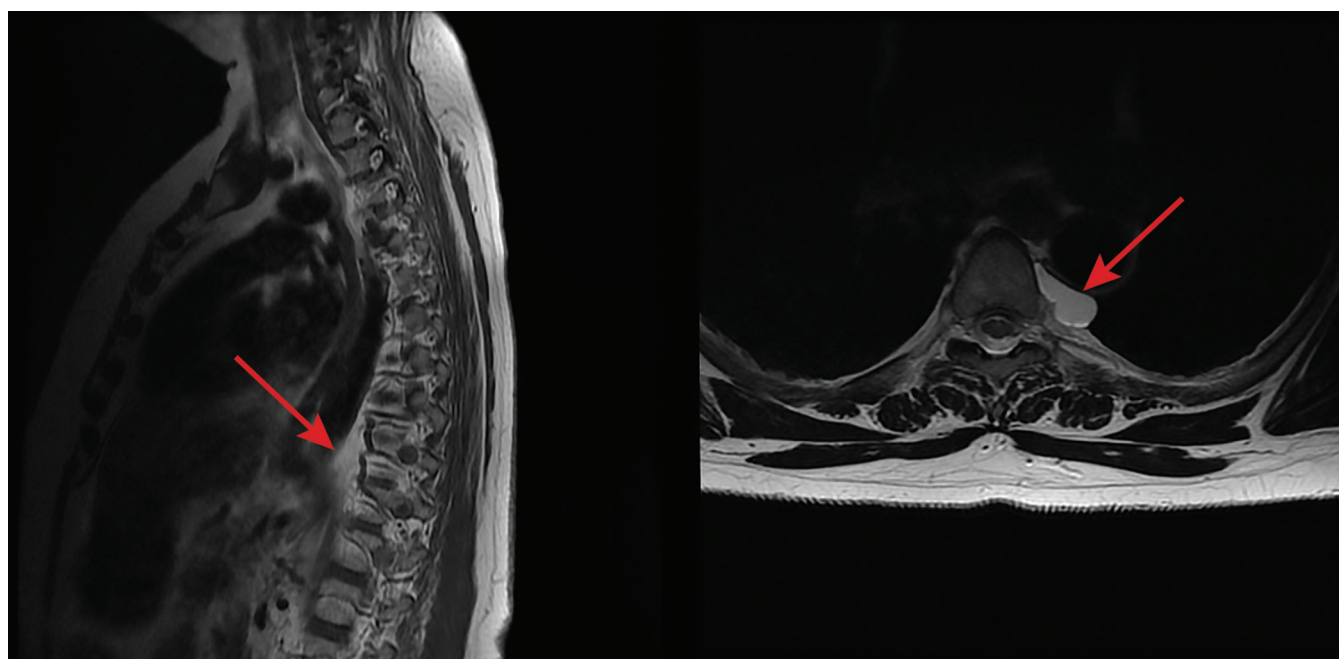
Chest MRI showed a cystic formation in the left paravertebral space at the level of 4th and 5th thoracic vertebrae.
